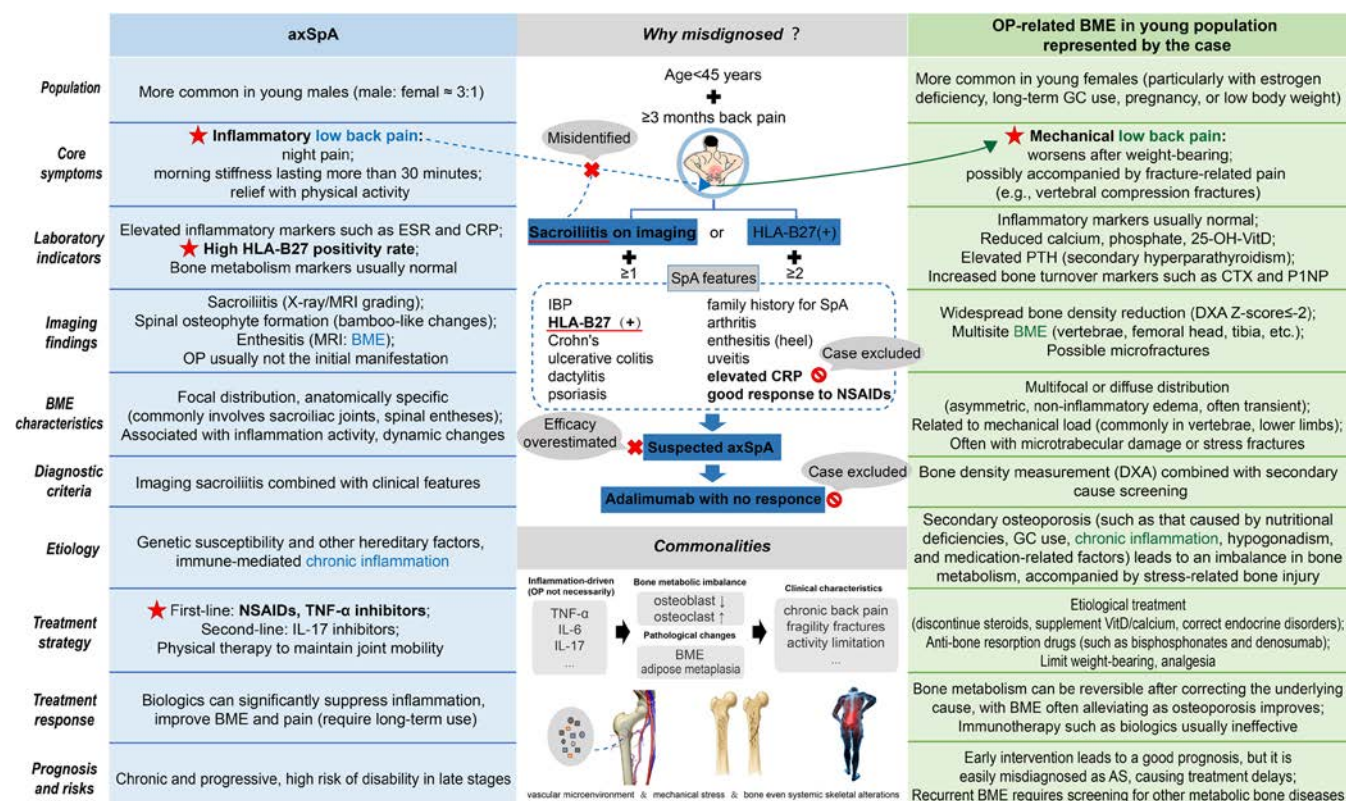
Commonalities and comparison of clinical features between axSpA and OP-related BME. BME, bone marrow edema; CRP, C-reactive protein; CTX, C-terminal telopeptide of type I collagen; DXA, dual-energy X-ray absorptiometry; ESR, erythrocyte sedimentation rate; GC, glucocorticoid; HLA-B27, human leukocyte antigen B27; IBP, inflammatory back pain; IL, interleukin; MRI, magnetic resonance imaging; NSAID, non-steroidal anti-inflammatory drug; OP, osteoporosis; PTH, parathyroid hormone; P1NP, procollagen type I N-terminal propeptide; SpA, spondyloarthritis; TNF-α, tumor necrosis factor-alpha; 25-OH-VitD: 25-hydroxyvitamin D.
